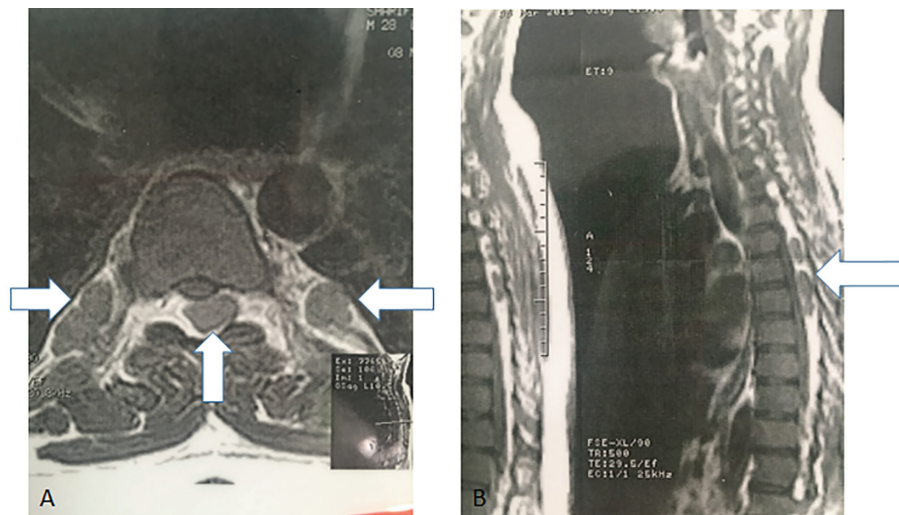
Axial and sagittal T1-weighted MR imaging before treatment with hydroxyurea. Extensive paraspinal and extradural intraspinal masses representing extra medullary hematopoiesis.
